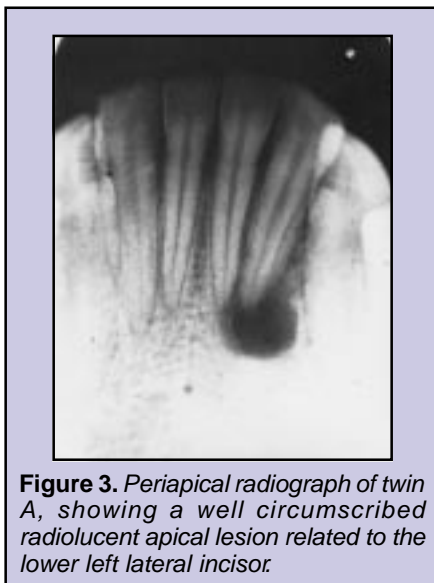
Periapical radiograph of twin A, showing a well circumscribed radiolucent apical lesion related to the lower left lateral incisor.
